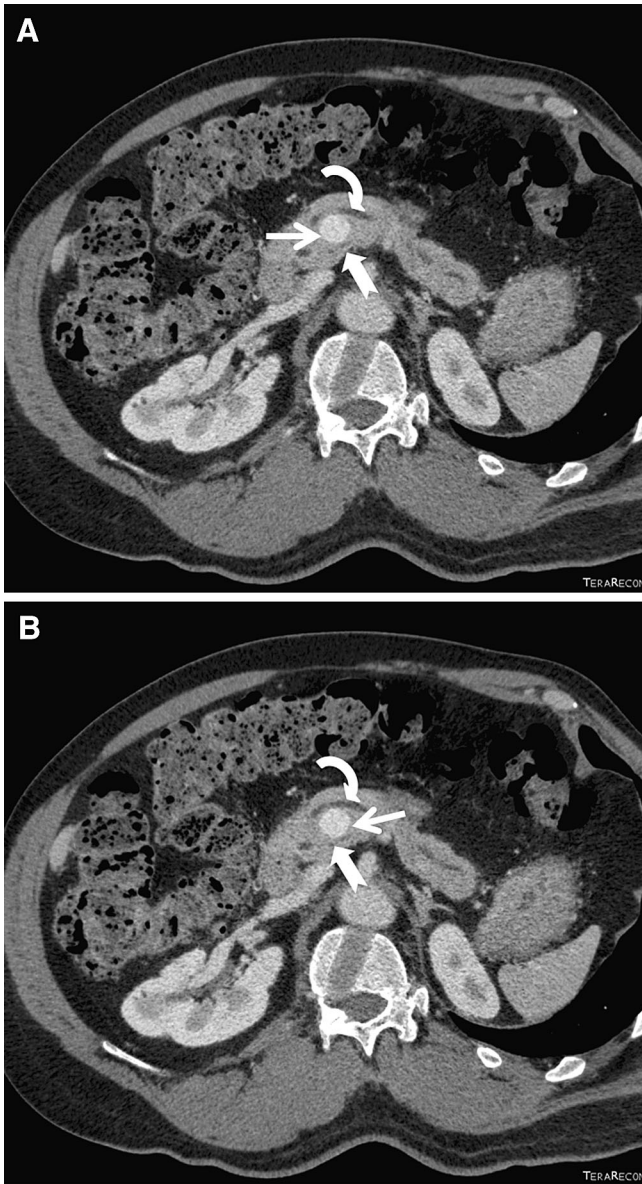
Accessory duct posterior to portal vein in a 64-year-old man with suprasplenic circumportal pancreas and anteportal duct. Axial oblique post-contrast CT images cranial to caudal (A–B). Accessory duct (*notched arrow*) courses posterior to the portal vein (*white arrow*). The main pancreatic duct (*curved arrow*) is anterior to the portal vein.
